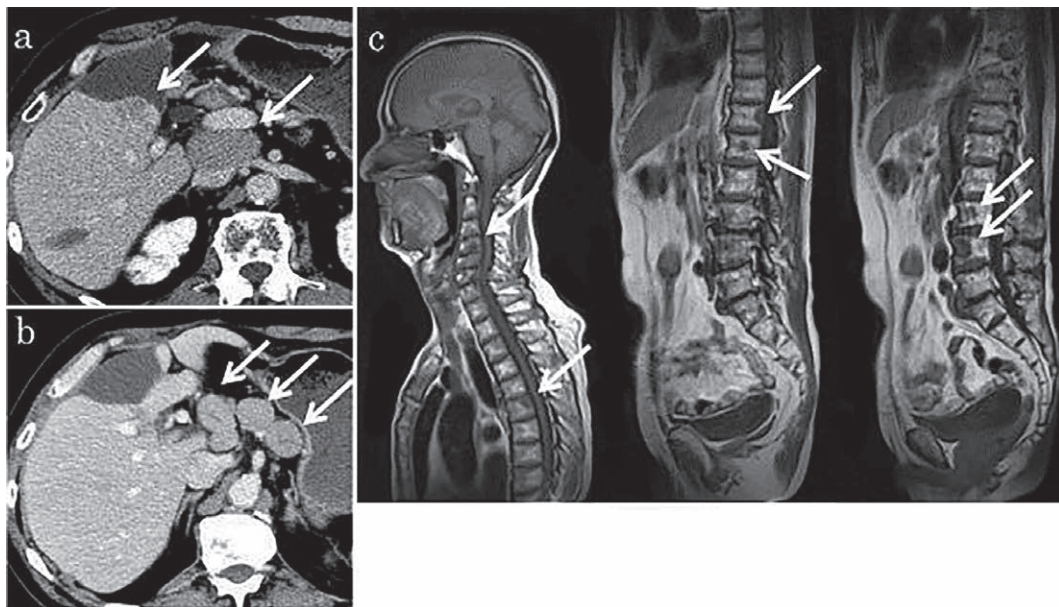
Baseline abdominal computed tomography (a, b), and whole-spine magnetic resonance imaging (c). Arrows show recurrence of hepatocellular carcinoma (12 mm) around the segment 5 operation site and multiple lymph node metastases around the liver (a, b), and multiple bone metastases in the spine (C3, Th4, L1, L2, L4 and L5).
